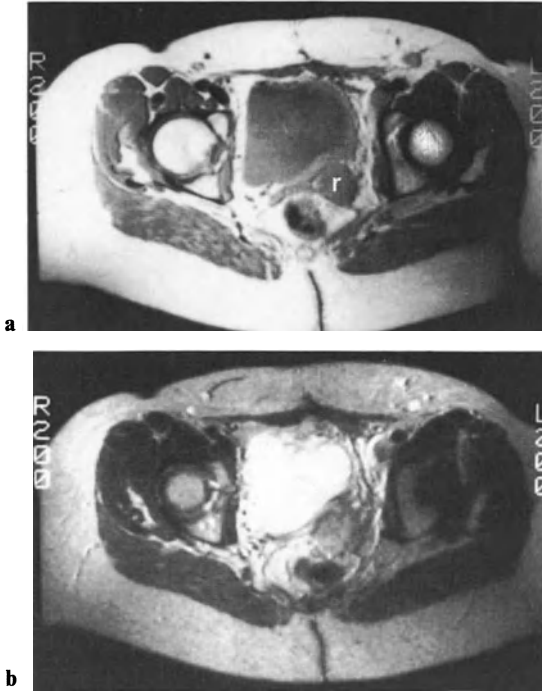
a, b. MRI: local recurrence after Wertheim's operation. a SE 2000/20, b SE 2000/80. Left-sided recurrence (*r*) with reactive swelling of the adjacent wall of the bladder
